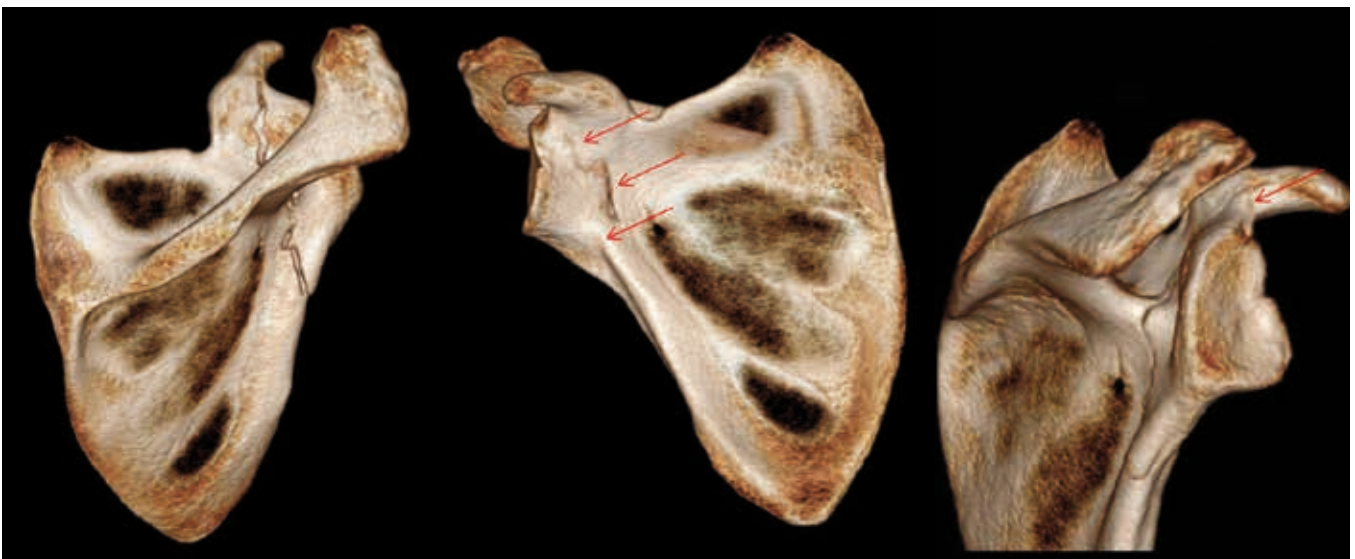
Undisplaced anatomical neck fracture on 3D CT reconstructions. Red arrows indicate the fracture line.
